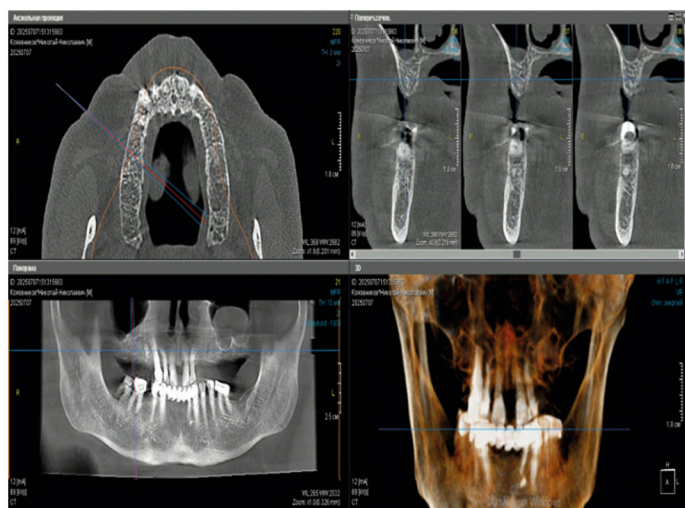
Results of CBCT of a 78-year-old patient with partial secondary adentia with severe chronic generalized periodontitis
